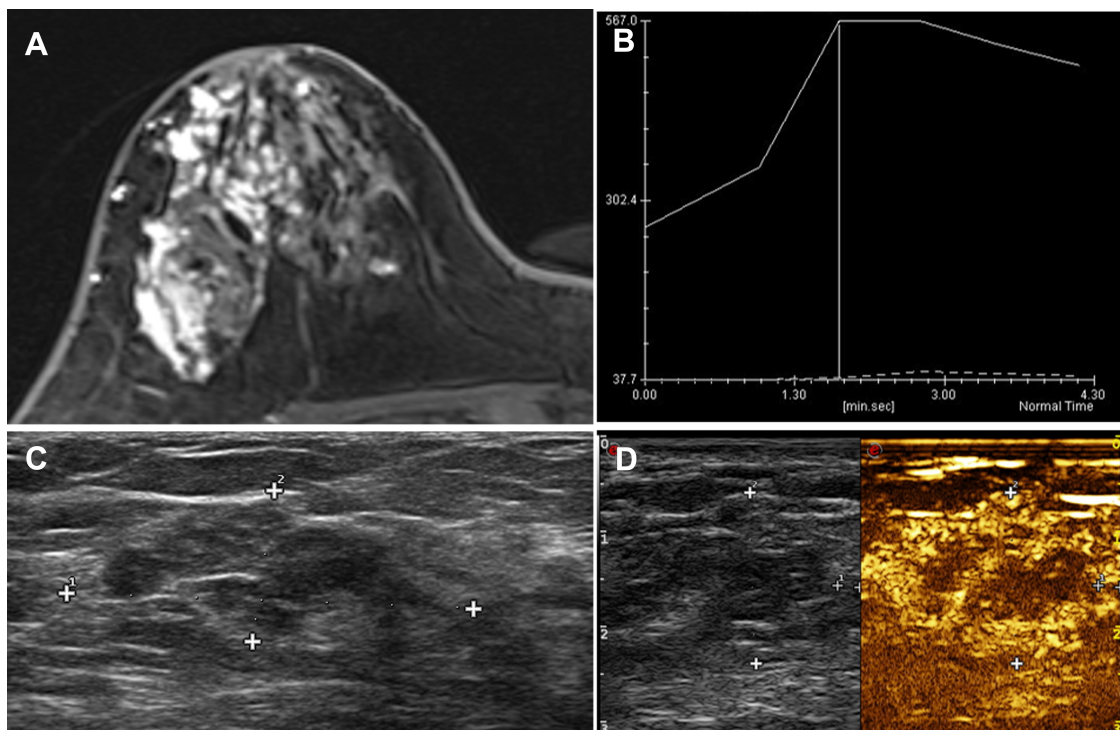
A 44-year-old female patient had progressive enlargement of her breast mass in the right upper outer quadrant for more than 1 year. (A) DCE-MRI showed a non-mass-like enhancement of about $86 \times 32 \times 43 \text{mm}$, and the boundary between the lesion and the surrounding structure is unclear. (B) The TIC curve was plateau type. (C) CEUS indicated that the heterogeneity of the right breast at 9 o'clock was a slightly hypoechoic nodule, (D) showing uneven hyperenhancement. The surrounding blood vessels were more disordered. An unenhanced area was found in the center, and the lesion area enlarged compared with conventional US. The pathology result is ductal carcinoma in situ (DCIS).
